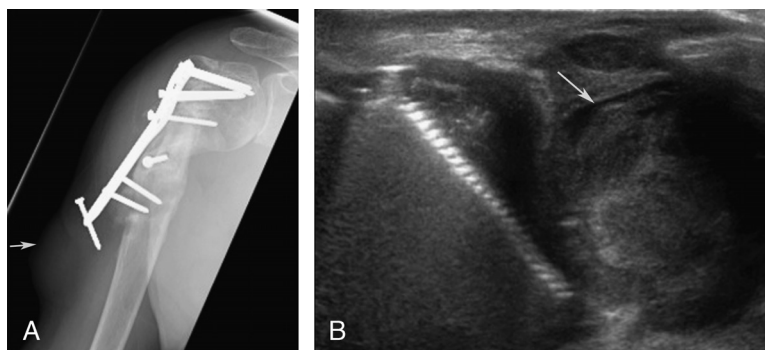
A. Radiograph demonstrates failure of the hardware with a soft tissue density superficial to the lowermost screw (*arrow*). B. Corresponding ultrasound shows a complex fluid collection (*arrow*) that was consistent with an abscess superficial to the screw. Note there is no sonographic artifact superficial to the screw, and thus the fluid collection is characterized.
